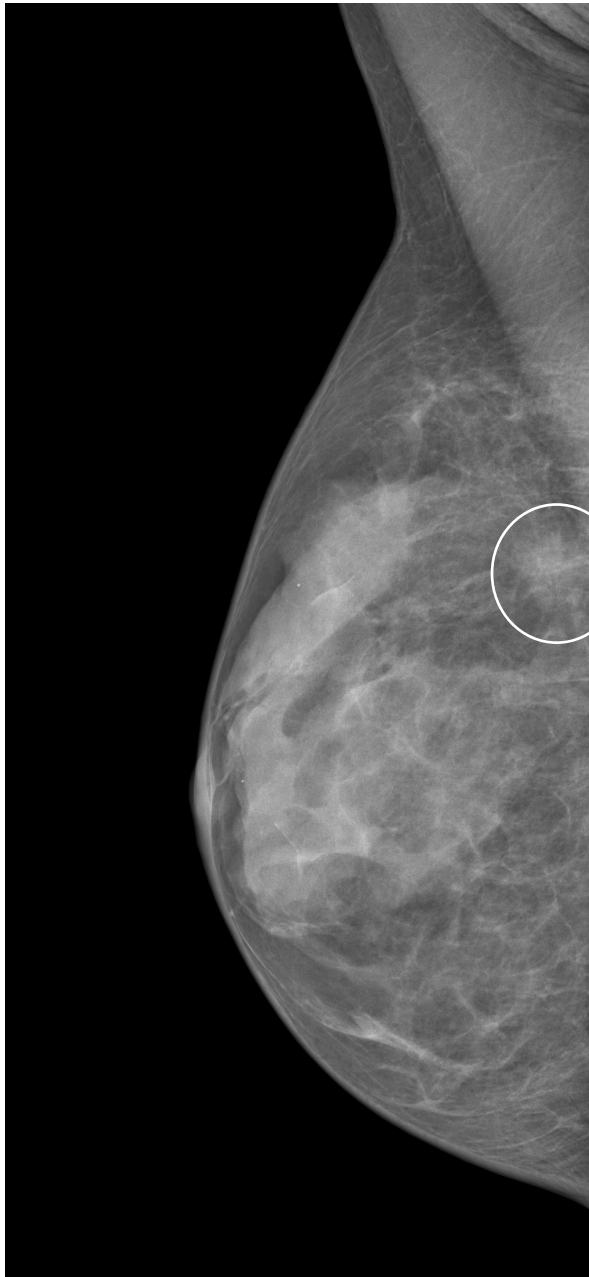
4-2.6 show images acquired of the same breast containing a 10 mm, grade 1, invasive lobular carcinoma using the below mentioned different imaging techniques. Besides these imaging techniques, breast imaging can also be performed using scintigraphy, magnetic resonance, computed tomography, optical imaging, among others.
